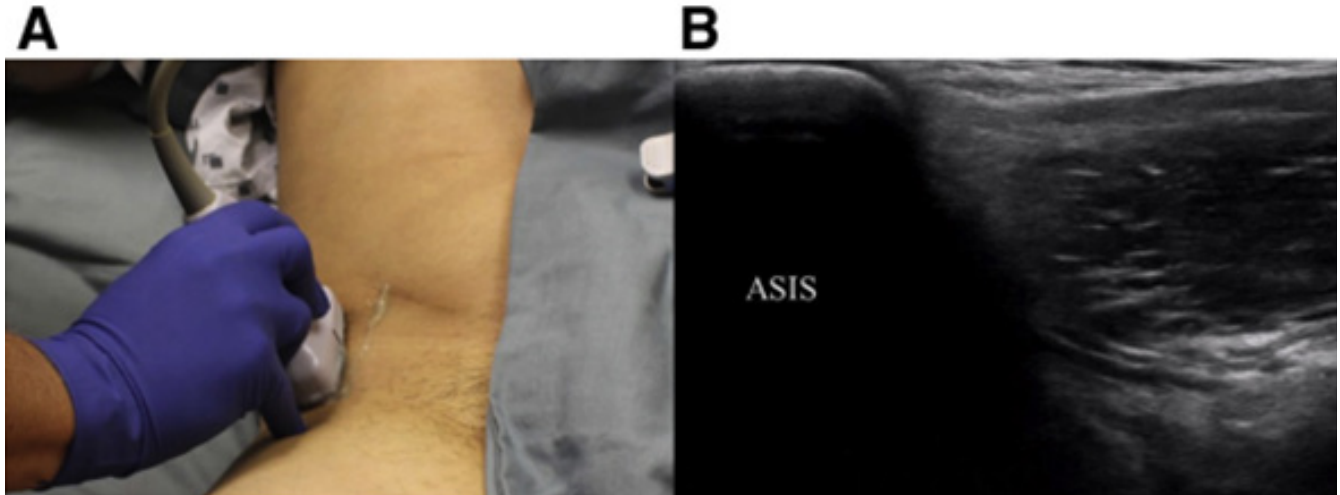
A. Placement of the probe longitudinally on the ESIA in the previously made mark. B. Ultrasound view of the upper pole of the ASE probe.
